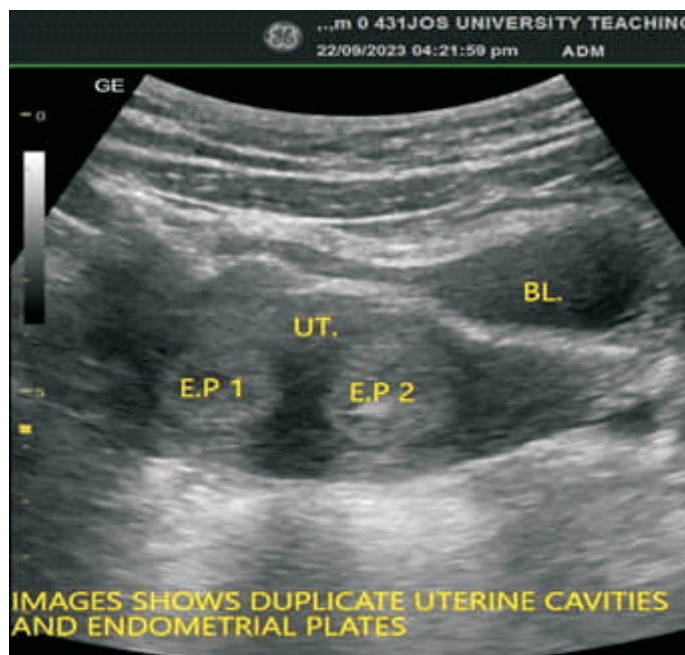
A grayscale transabdominal transverse sonogram of the uterus (UT) demonstrating two endometrial complexes (E.P 1 and E.P 2) separated by myometrial tissue.
